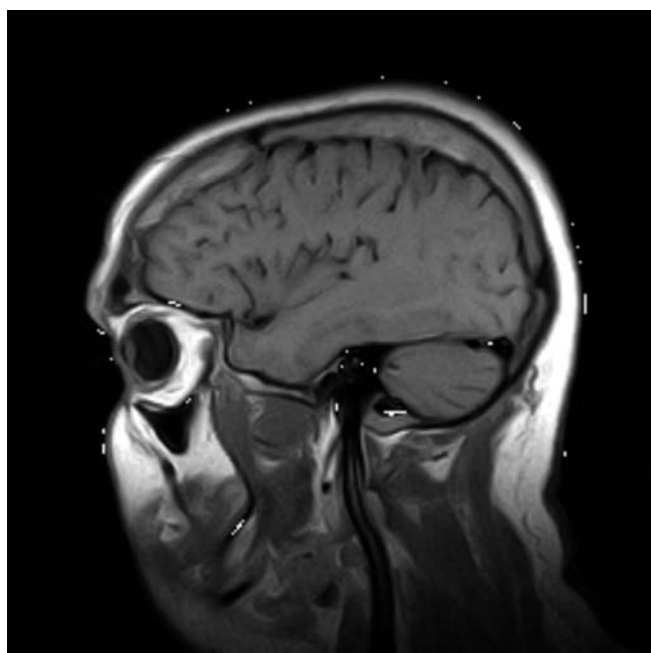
Sagittal T1-weighted MRI shows hypertrophic frontal bone
